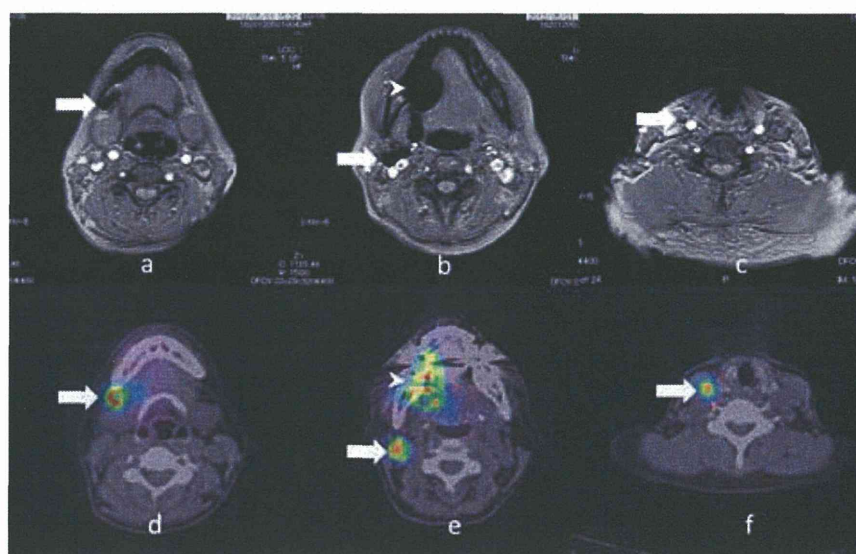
Arrows show sentinel nodes (SNs) in the right, level IB (a, d), IIA (b, e), III (c, f) region of the neck. SNs detected on fast-field echo (FFE) T1-weighted images at 10 min after injection of superparamagnetic iron oxides were completely concordant with those detected by single photon emission computed tomography (SPECT)/computed tomography (CT) using radiocolloids in the right, level IB, IIA, III region. Arrowhead shows injected site of the tongue. Although streak artifacts were seen around the injection site, they did not impair detection of SNs near the injection site. (a, b, c: FFE T1-weighted images at 10 min; d, e, f: SPECT-CT image of ^{99m}Tc -radiocolloid).
